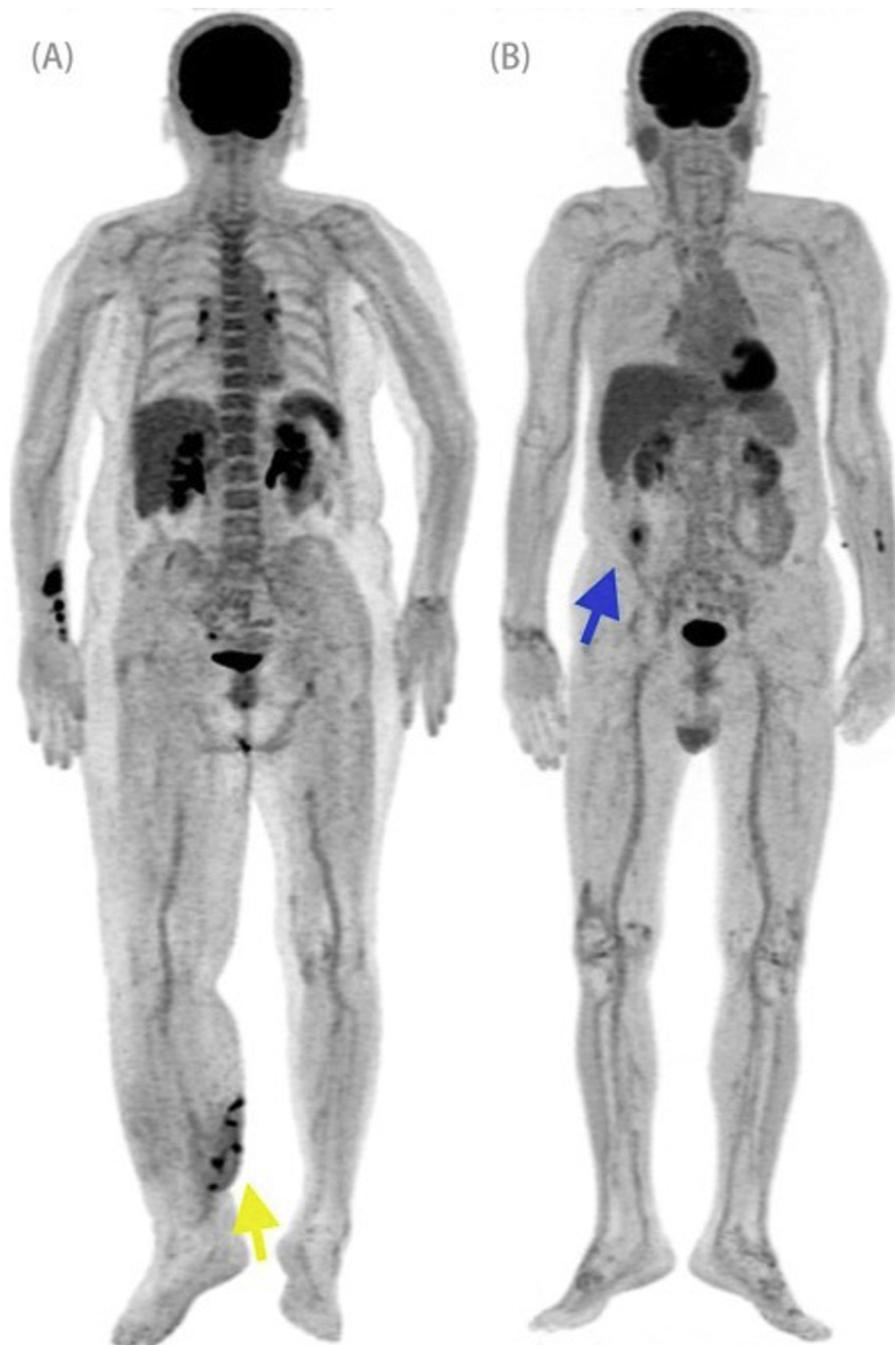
^{18}F -FDG PET coronal views of two patients with positive findings and different splenic FDG uptake intensities. (A) A 67-year-old female patient presented with high CRP levels (75 mg/L) at admission. ^{18}F -FDG PET revealed prominent splenic uptake accompanied by avid focal ^{18}F -FDG uptake in the right calf (yellow arrow). (B) A 73-year-old male patient presented with low CRP levels (2.6 mg/L) at admission. The splenic uptake of ^{18}F -FDG was less prominent than that observed in the liver; in addition, focal ^{18}F -FDG uptake in the right ascending colon was evident (blue arrow).
